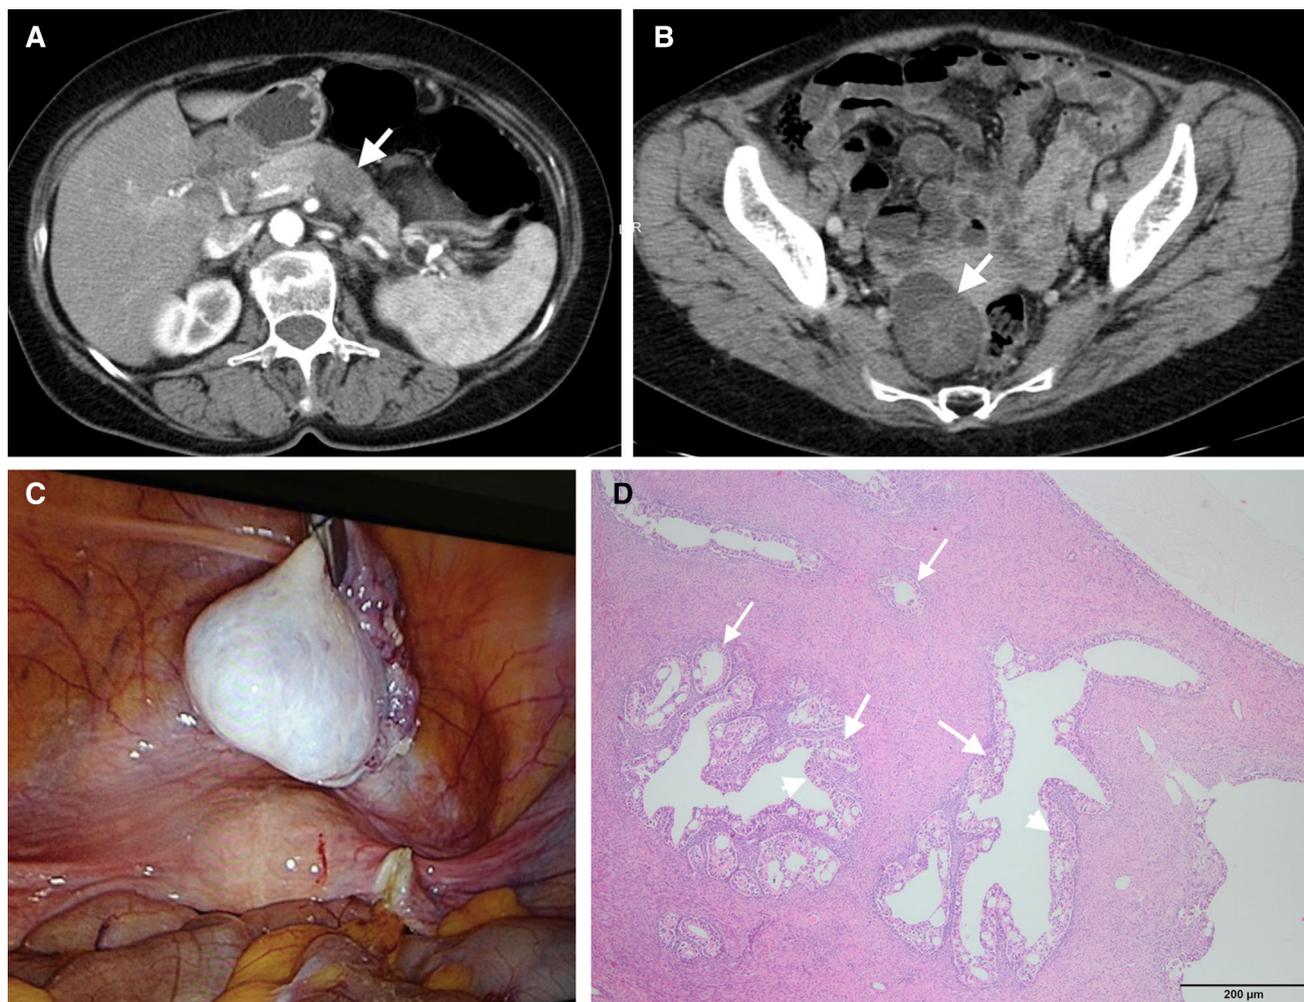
Fifty-five-year-old woman, with no significant medical history, presented with weight loss and epigastric pain. A Axial post-contrast CT image reveals a hypodense solid mass (arrow) within the pancreatic body. Subsequent percutaneous biopsy showed that the lesion was a pancreatic adenocarcinoma. B Axial
